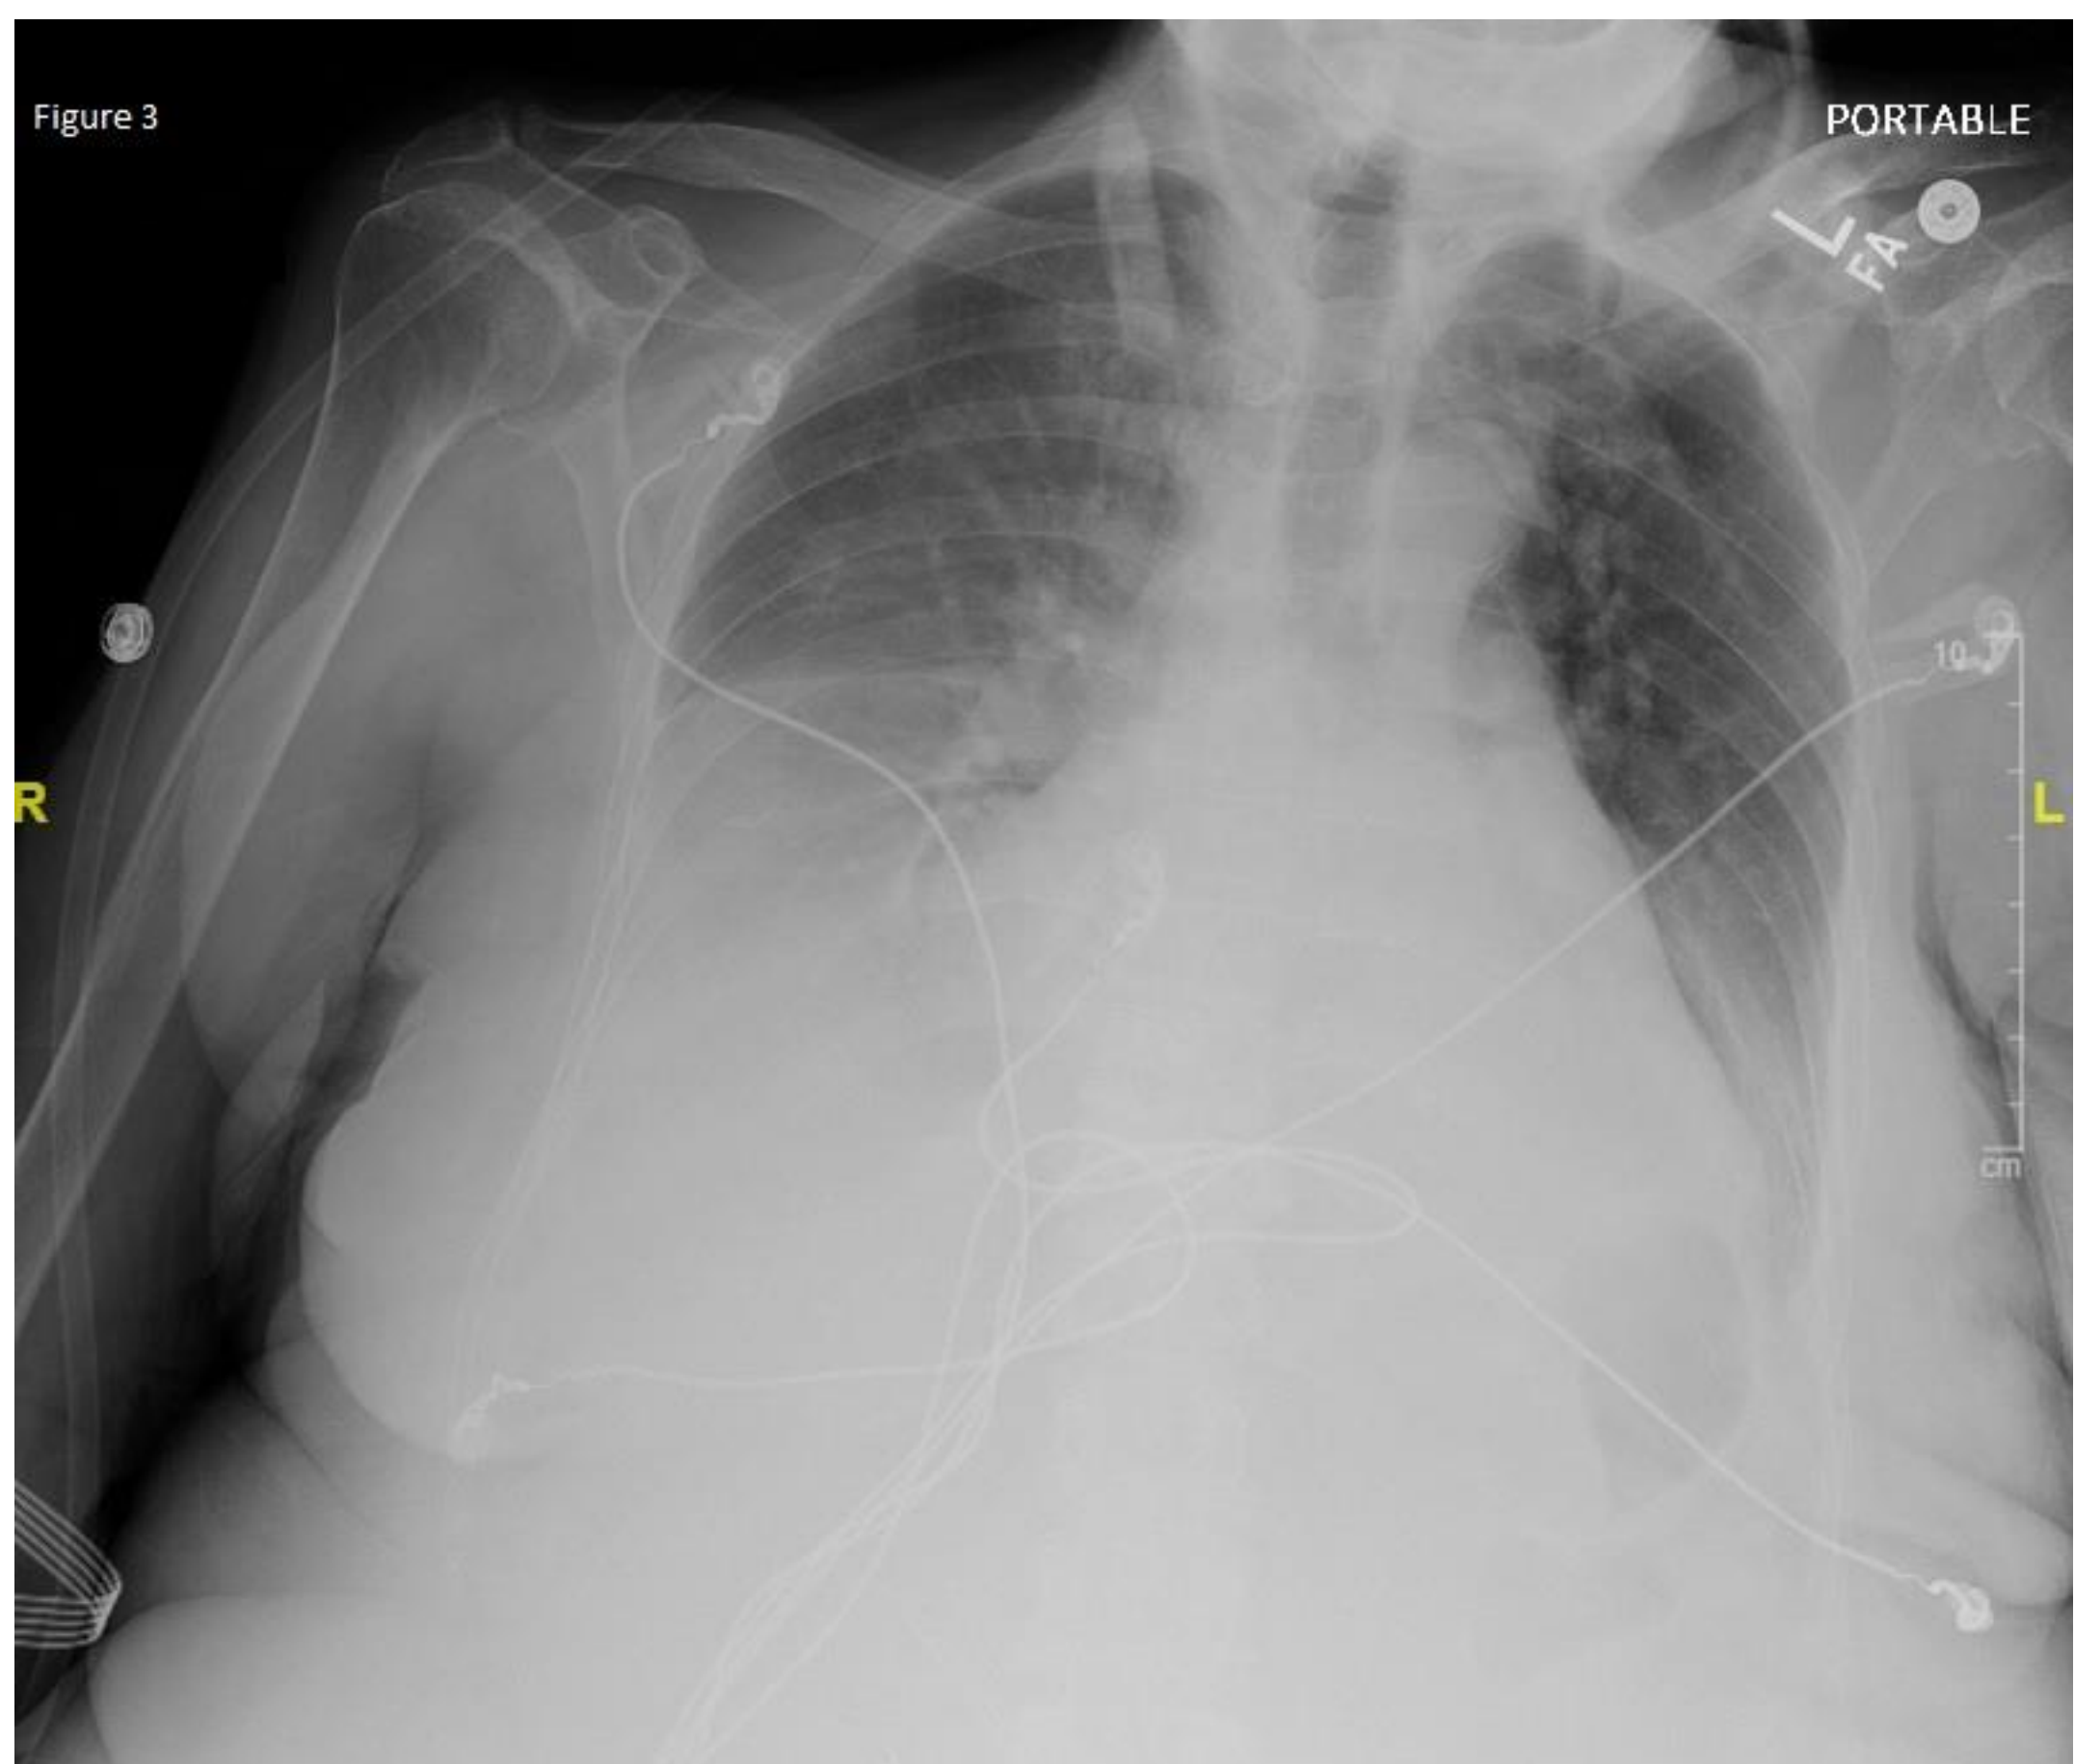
Chest X-ray post ERCP with bilateral pleural effusions
